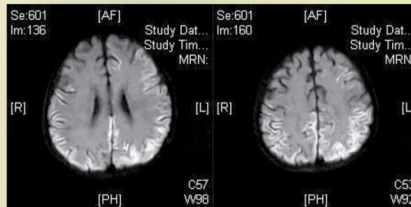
DWI. More extensive restricted diffusion along bilateral cerebral gyri and subcortical white matter and new restricted diffusion at bilateral insular cortex and caudate nuclei.
